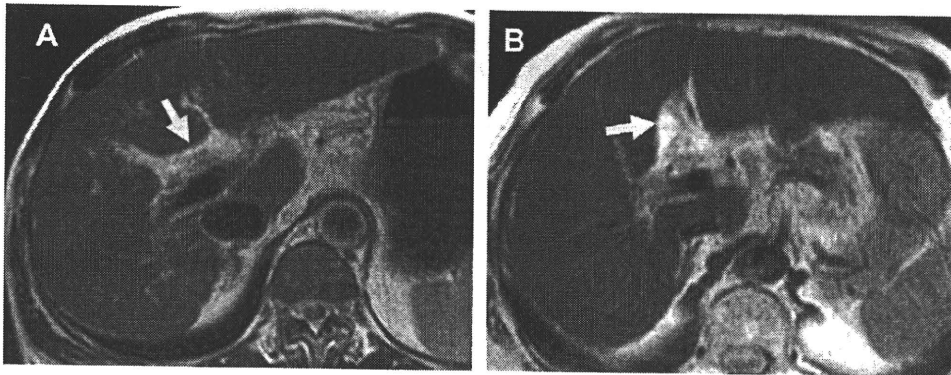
T2-weighted TSE image in early cirrhosis shows enlargement of the hilar periportal space between the left medial segment and the right portal vein (A) (arrow) and expansion of the major interlobar fissure (B) (arrow) between the left medial and lateral segments.
